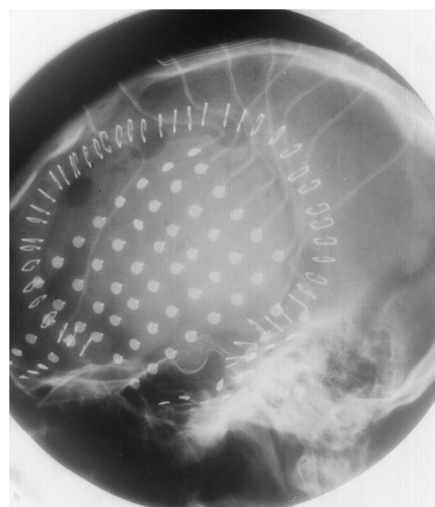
Grid on surface of brain for EEG seizure mapping and for mapping of eloquent cortex with electrical stimulation as seen on plain lateral skull radiograph.
